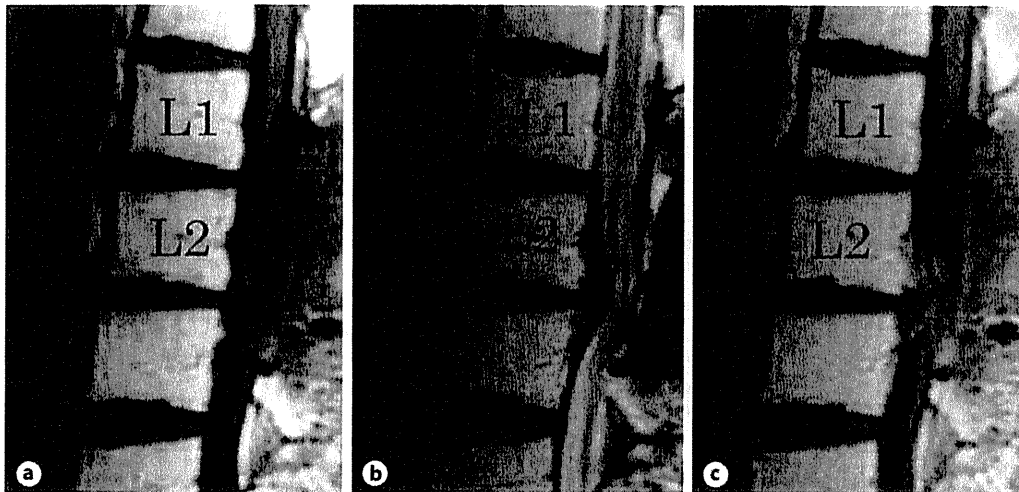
MRI after chemotherapy and radiation. a T1-weighted image. b T2-weighted image. c T1-weighted image with gadolinium enhancement.
